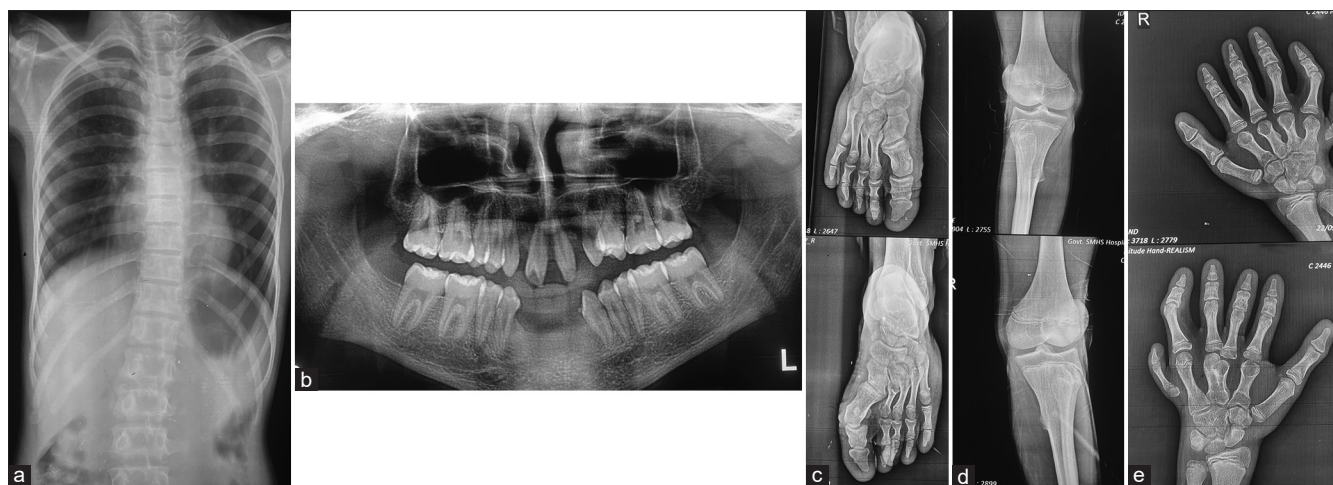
(a) PA view of the chest X-ray showing a narrow chest and short ribs. (b) Panoramic radiograph showing agenesis of the maxillary lateral incisors, mandibular incisors, and all four third molars. (c) X-rays of the hands showing postaxial polydactyly, short middle, and distal phalanges with cone-shaped epiphyses and carpal fusion. (d) X-rays of the feet showing bilateral hallux valgus deformity of the great toes. (e) X-rays of the legs showing lateral tibial metaphysis slanted giving rise to a genu valgum deformity.
